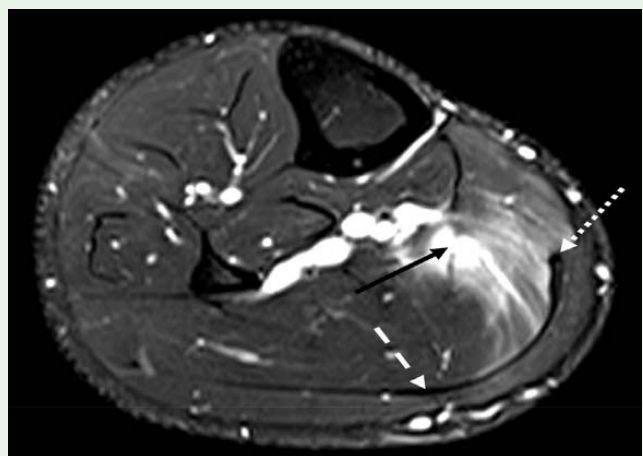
24-year-old elite national ARF player with recurrent calf tears. Axial T2 FS MRI of the right calf showing a tear of the posterior aspect of the medial soleus intra-muscular aponeurosis (black arrow). Fluid is seen tracking directly along perimysial planes directly to focal scarring of the medial calf aponeuroses and plantaris tendon complex (dotted arrow). The player underwent medial calf adhesiolysis of plantaris and medial calf aponeurosis scarring with 20cc normal saline with improvement in knee to wall measurement from 13 to 16 cm. Initial rehabilitation was affected by unrelated injury. Large volume adhesiolysis (60cc) for more extensive aponeurotic scarring (dashed arrow) thought to be contributing to recurrent right calf tears at the lateral soleus intramuscular and plantaris-medial calf aponeuroses was subsequently been preformed with clinical improvement.
